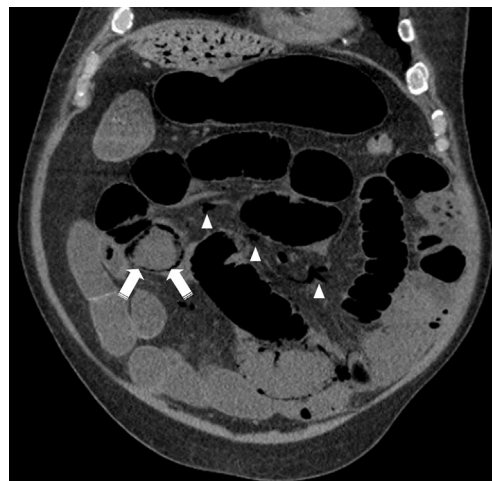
Noncontrast CT of the abdomen (coronal view), demonstrating gas in the mesenteric venous system (arrowheads) and diffusely dilated loops of bowel with pneumatosis (arrows).
